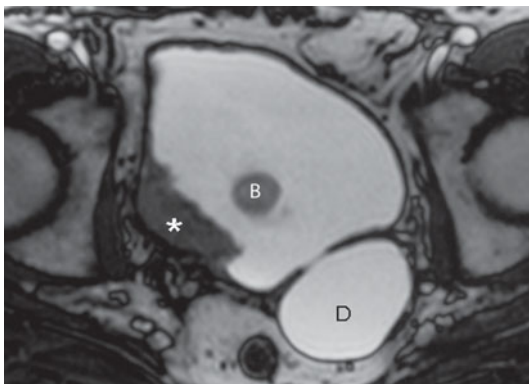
Magnetic resonance. Bladder cancer. T2-weighted sequence shows an evident broad-based lesion projecting into the bladder lumen at the right posterolateral aspect (*asterisk*). A large diverticulum (*D*) is visible with the neck at the left posterolateral wall. *B*, balloon of the bladder catheter
